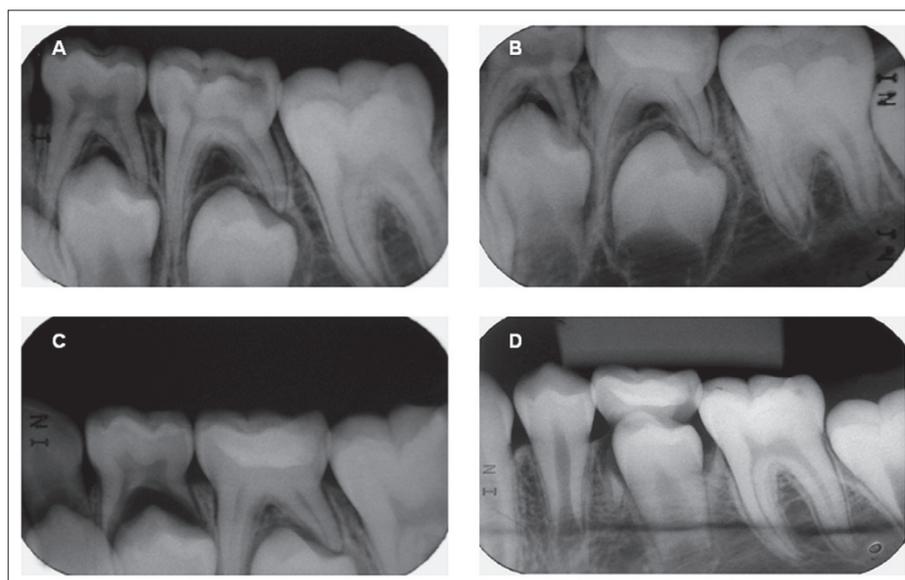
Pulpotomy treatment performed in a mandibular left primary second molar with the use of PC in an 8-year-old female patient. (A) Preoperative periapical radiograph of the tooth showing an extensive caries lesion, more than two thirds of root length, and no signs of periapical lesion. (B) Immediate postoperative periapical radiograph of the pulpotomised tooth with PC. (C) 12-month follow-up periapical radiograph suggesting the absence of periapical lesion in the pulpotomised molar and the progressive resorption of the roots, mainly the distal one, due to the eruption of the permanent successor. (D) 24-month follow-up periapical radiograph showing the complete resorption of the roots of the pulpotomised tooth caused by eruption of the permanent successor
